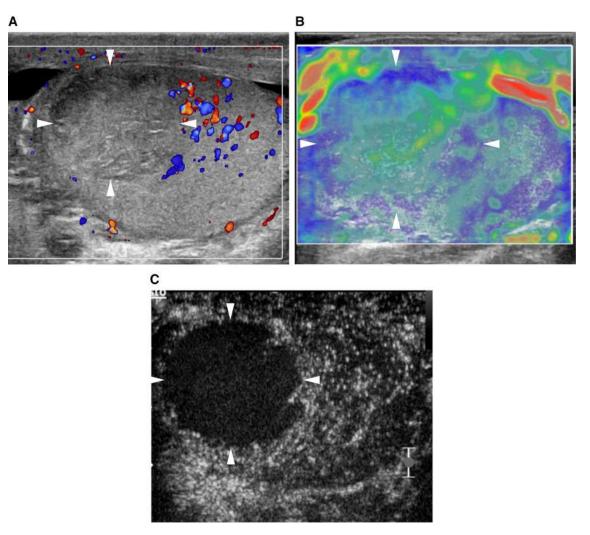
Segmental testicular infarction in a patient presenting with right acute scrotal pain lasting for 2 h. A Color Doppler ultrasonography reveals a slightly inhomogenous, barely visible area (arrowheads) in the upper pole of the testis in which
